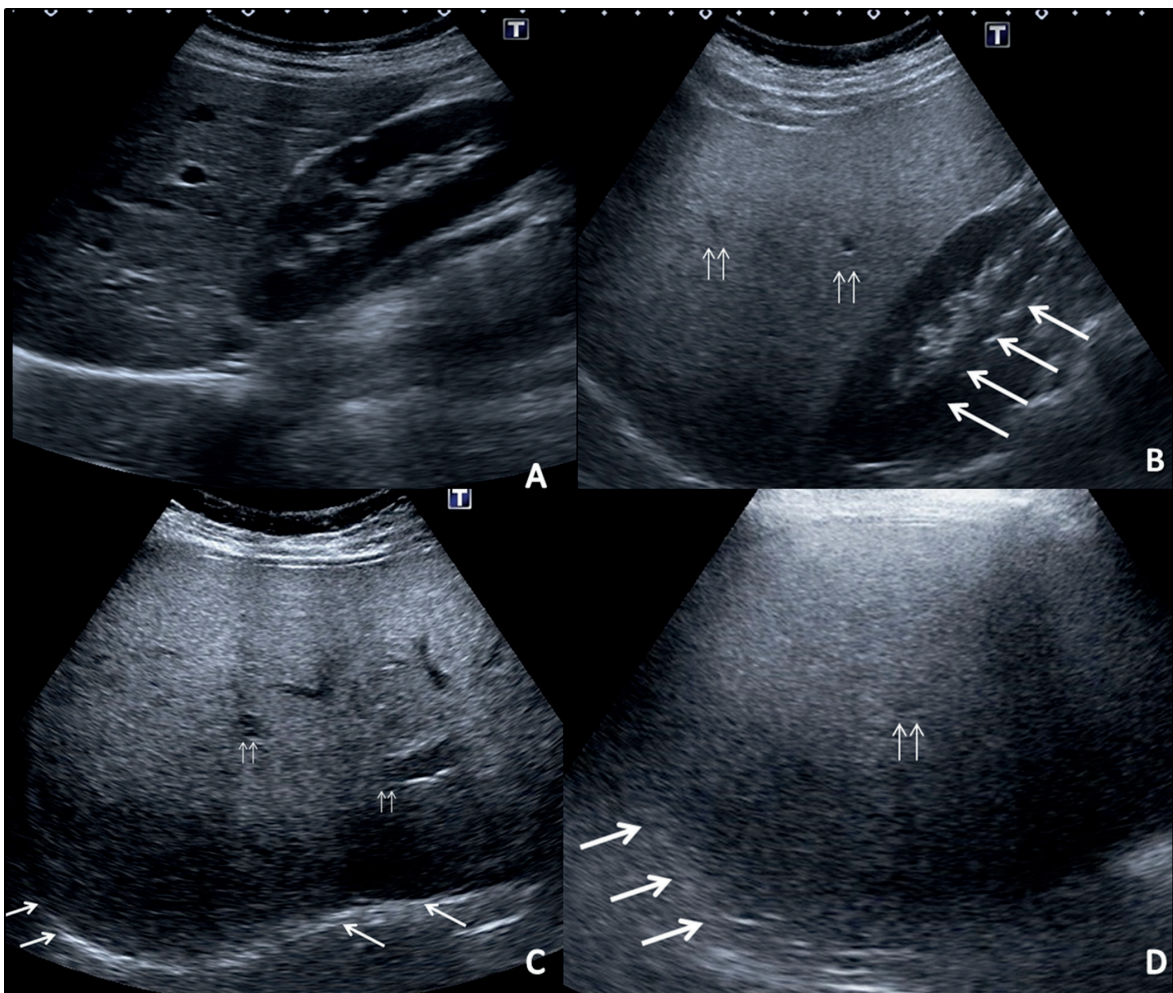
Assessment of hepatosteatosi on ultrasonography. A. Ultrasonographic appearance of a healthy liver. The borders of liver and vascular structures are clearly seen. B. 10-year-old boy with grade 1 hepatosteatosi. The echogenicity of the liver is higher than that of the right kidney cortex (thick arrows). Note that intrahepatic vessels can be seen (thin arrows). C. Grade 2 hepatosteatosi. The liver is diffusely hyperechogenic, but diaphragm (thick arrows) and intrahepatic vessels (thin arrows) are still seen. Hyperechogenic portal vein wall is obscured due to increased fatty infiltration (thin arrows). D. Grade 3 hepatosteatosi. The echogenicity of the liver is increased due to diffuse fatty infiltration that hindered the visualization of the diaphragm (thick arrows) and intrahepatic vessels (thin arrows) by attenuating ultrasound waves.
